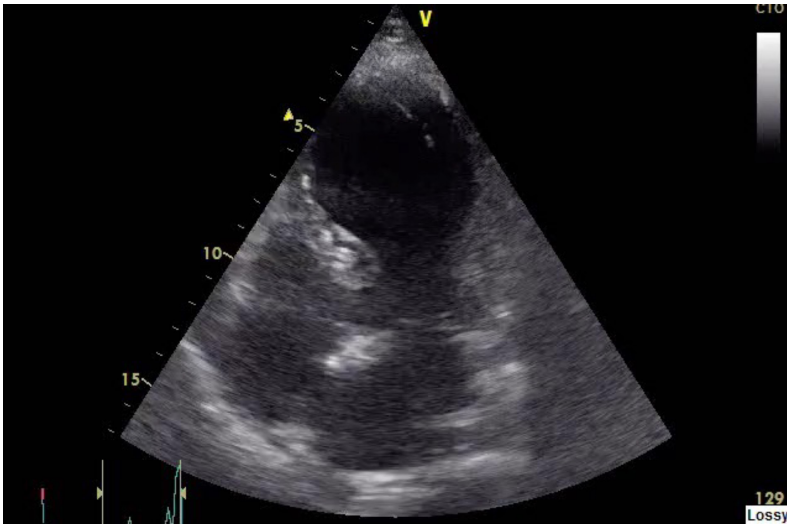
Transthoracic echocardiogram (Apical four chambers view) showing apical ballooning of left ventricle.
